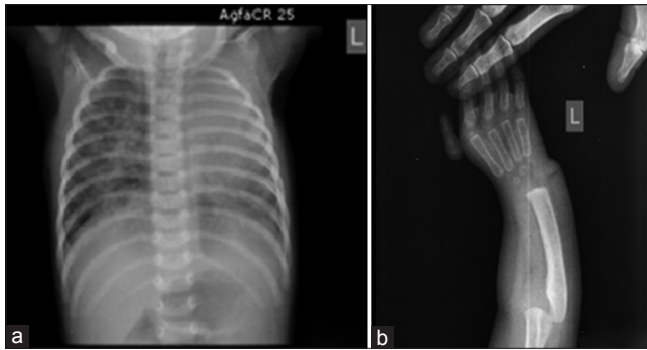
(a) Preoperative X-ray of patient. (b) X-ray of forearm bones
